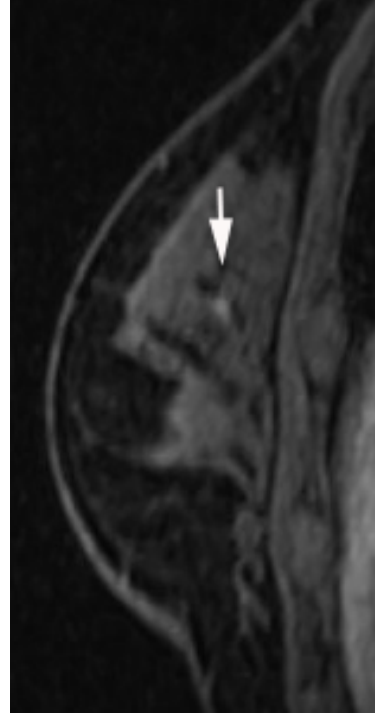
ENHANCING ASYMMETRY – Seen as enhancing mass on post contrast T1 weighted MRI sagittal image (arrow). Pathology: invasive ductal carcinoma.
